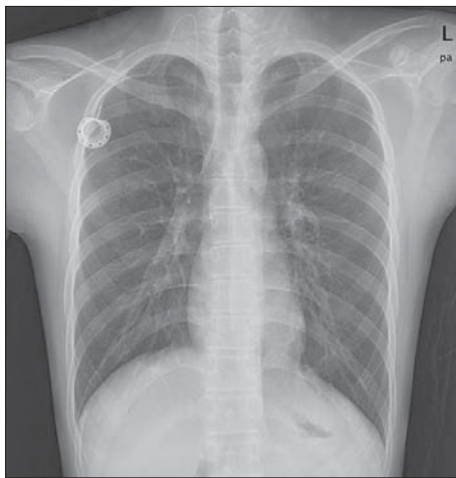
Tip of TIVAD is well in position in superior vena cava at postoperative chest radiography.
